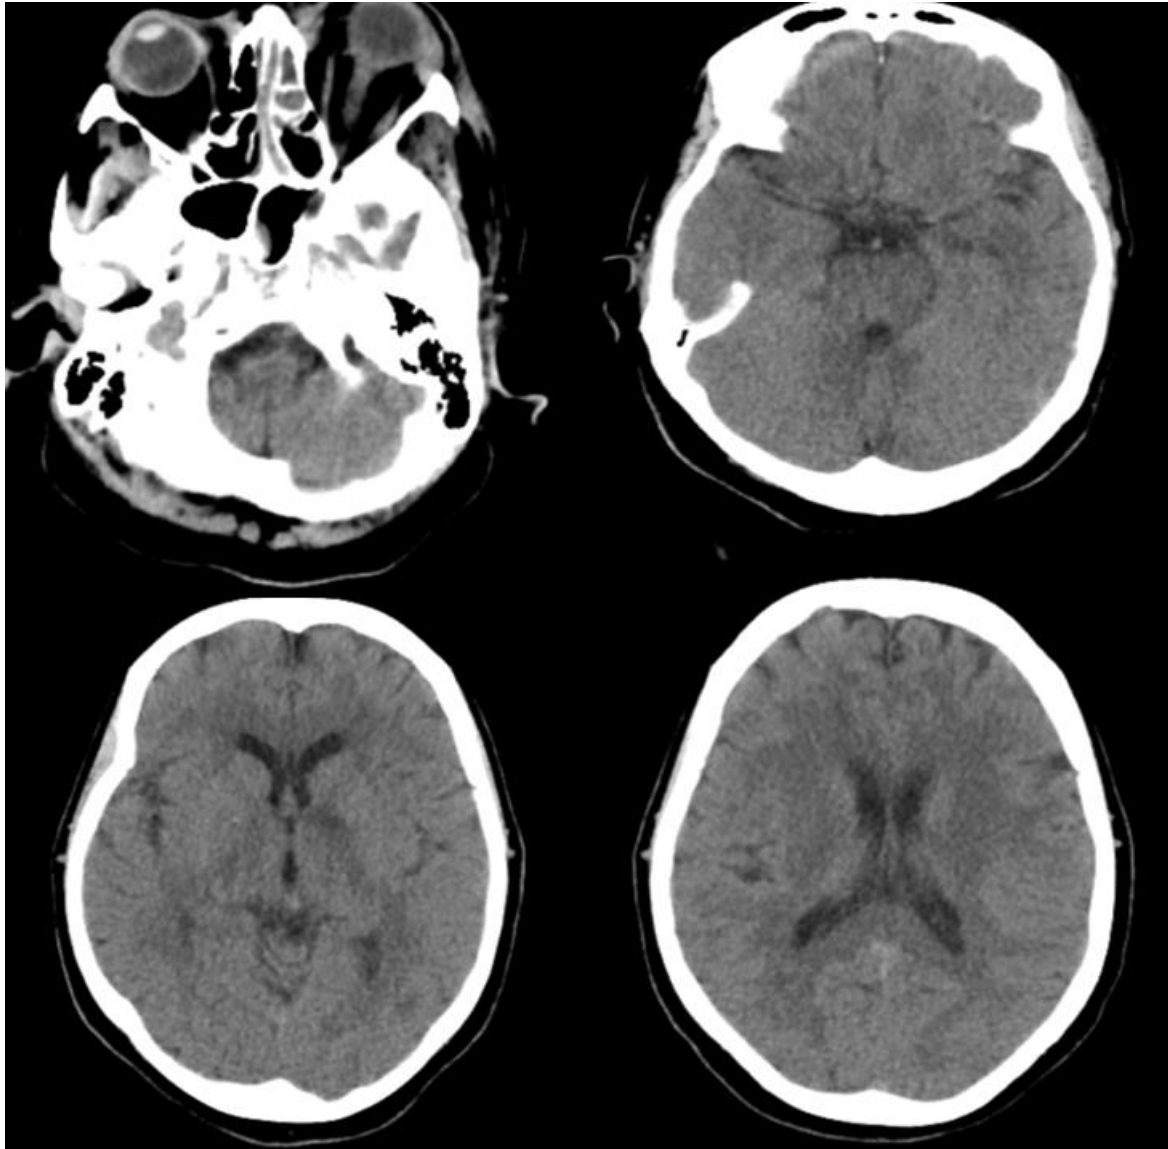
Brain CT showed normal ventricles and sulci, without midline shift. But vasogenic edema was present in the basal ganglia and frontoparietal lobe.
